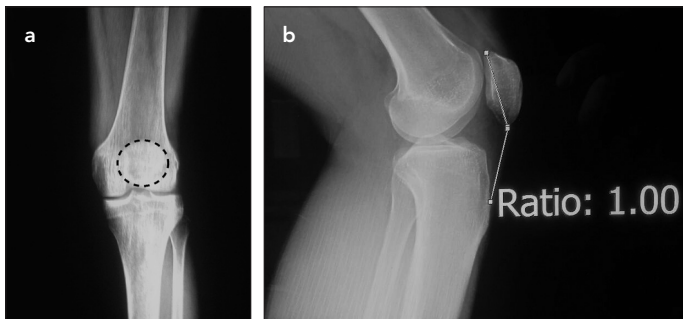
a, b. (a) After previous patellar dislocation, AP direct radiography view (yellow lines: projection of the patellar margin). (b) After previous patellar dislocation, lateral direct radiography view. AP: acute patellar
